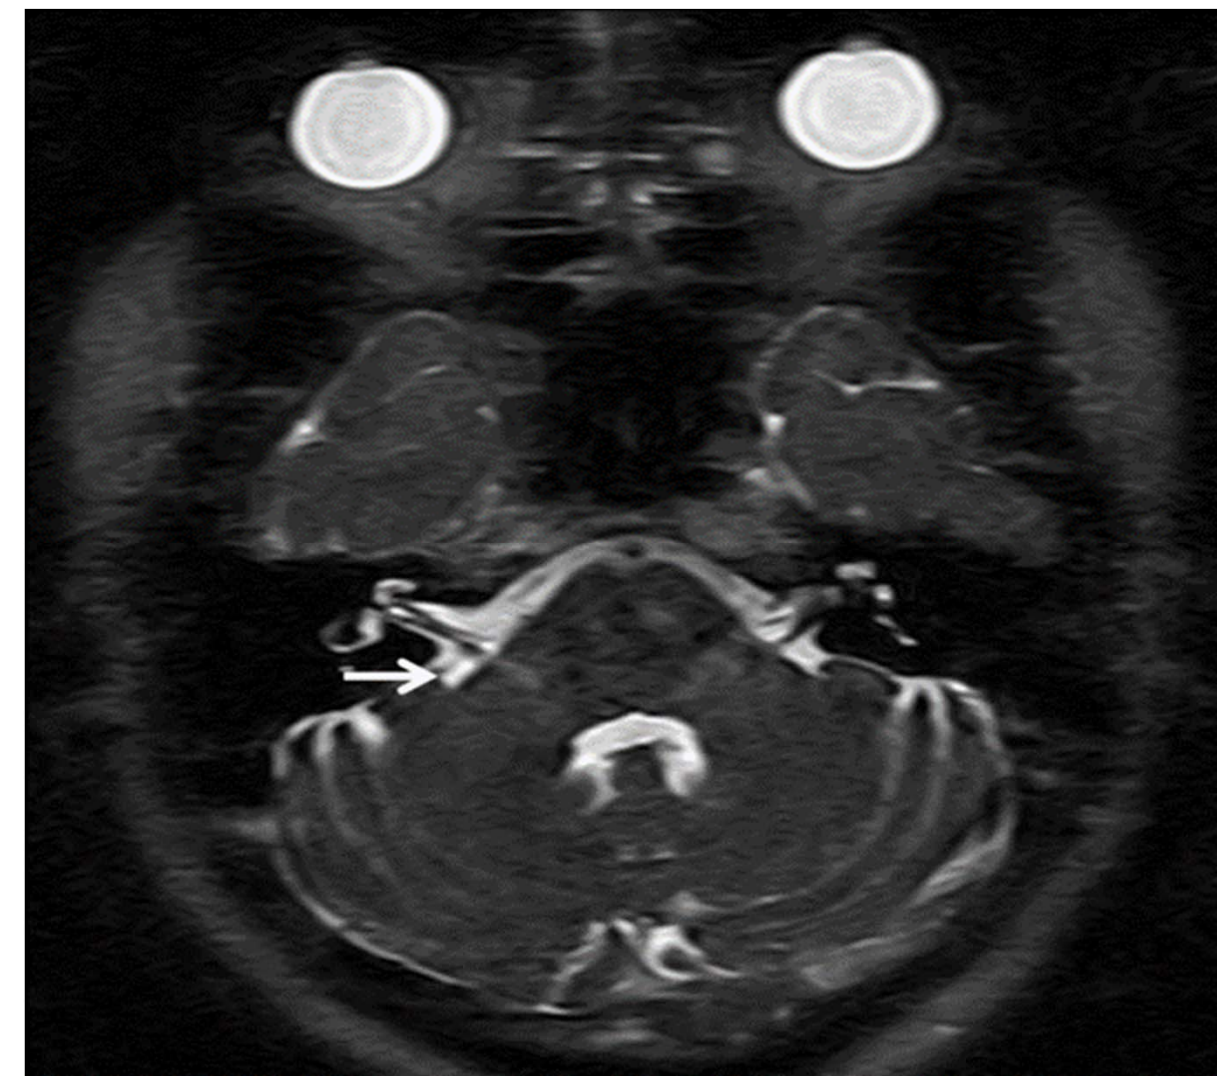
Note the loop of the anterior inferior cerebellar artery (AICA) (arrow) sitting at the porous acousticus in contact with the cochleovestibular nerve. There was bilateral compression of CN VIII on FIESTA MRI.
